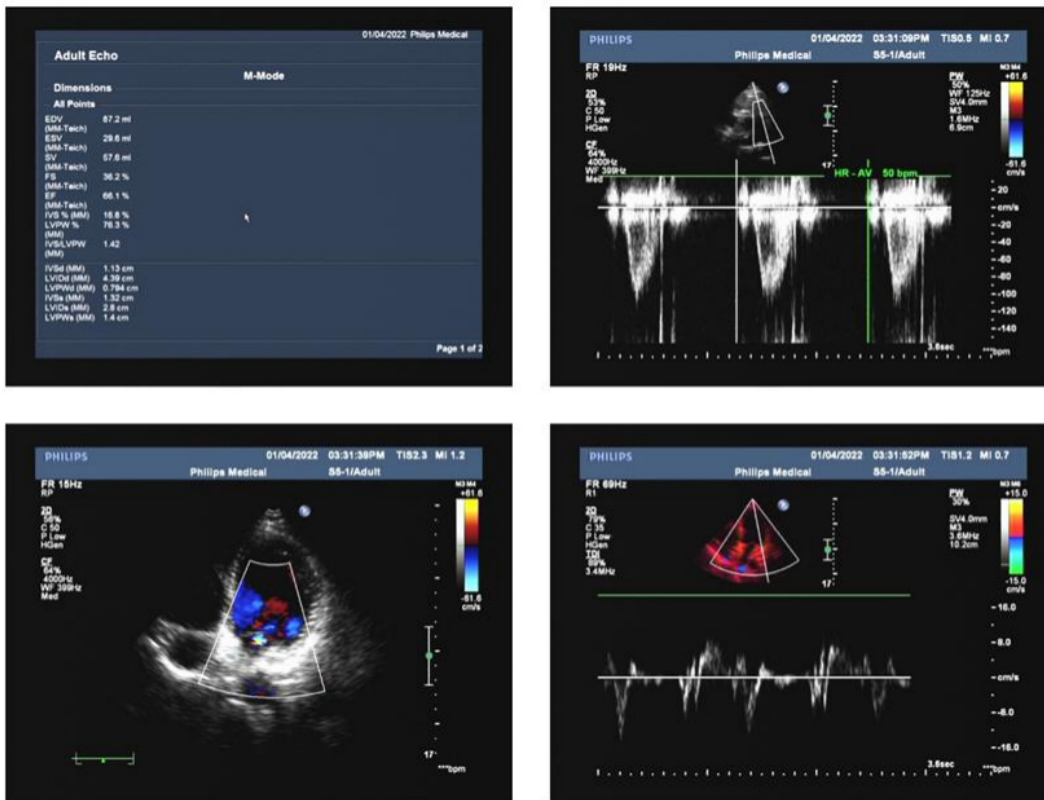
Echocardiography at follow-up suggested no residual shunt.
